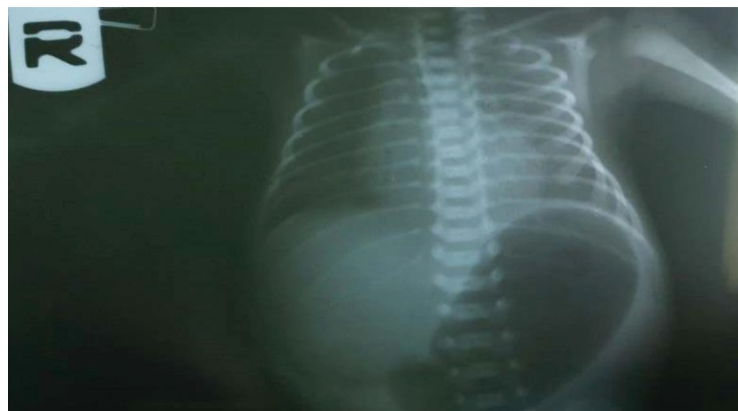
Thoracoabdominal x-ray
